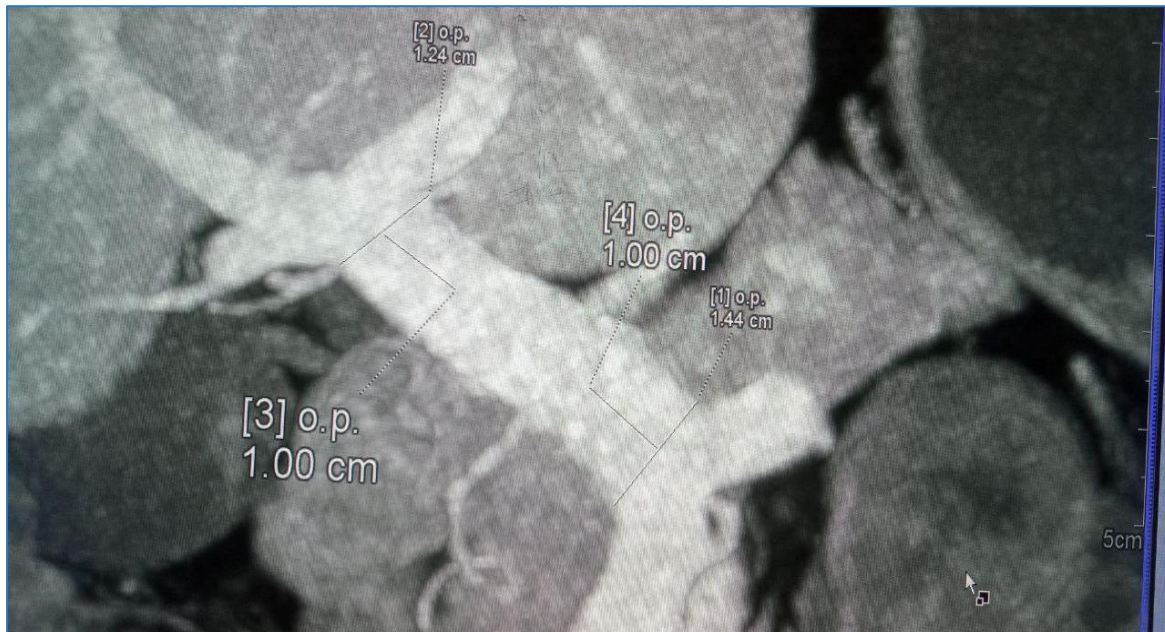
Coronal reformatted CT image for determination of level of main portal vein diameter measurement
